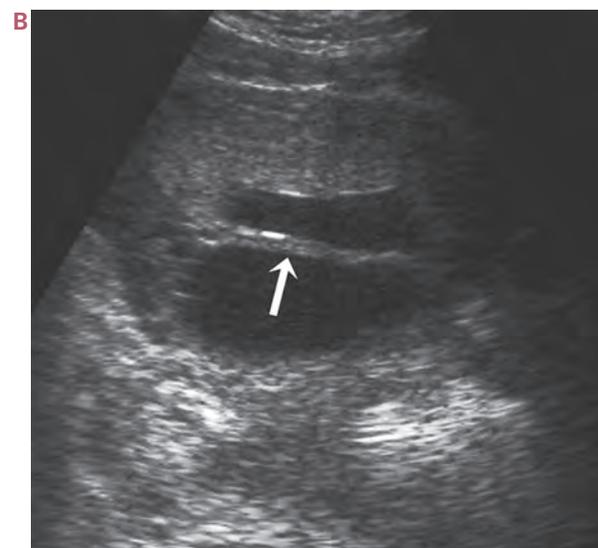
A Amniotic sheets are thought to be amnion and chorion folded over a uterine synechia. Reprinted with permission from Nelson LH: *Ultrasonography of the Placenta—A Review*. Laurel, MD, AIUM, 1994, p 42. B and C Thick strands represent amniotic sheets (arrow) resulting from scarring of the uterine cavity.
